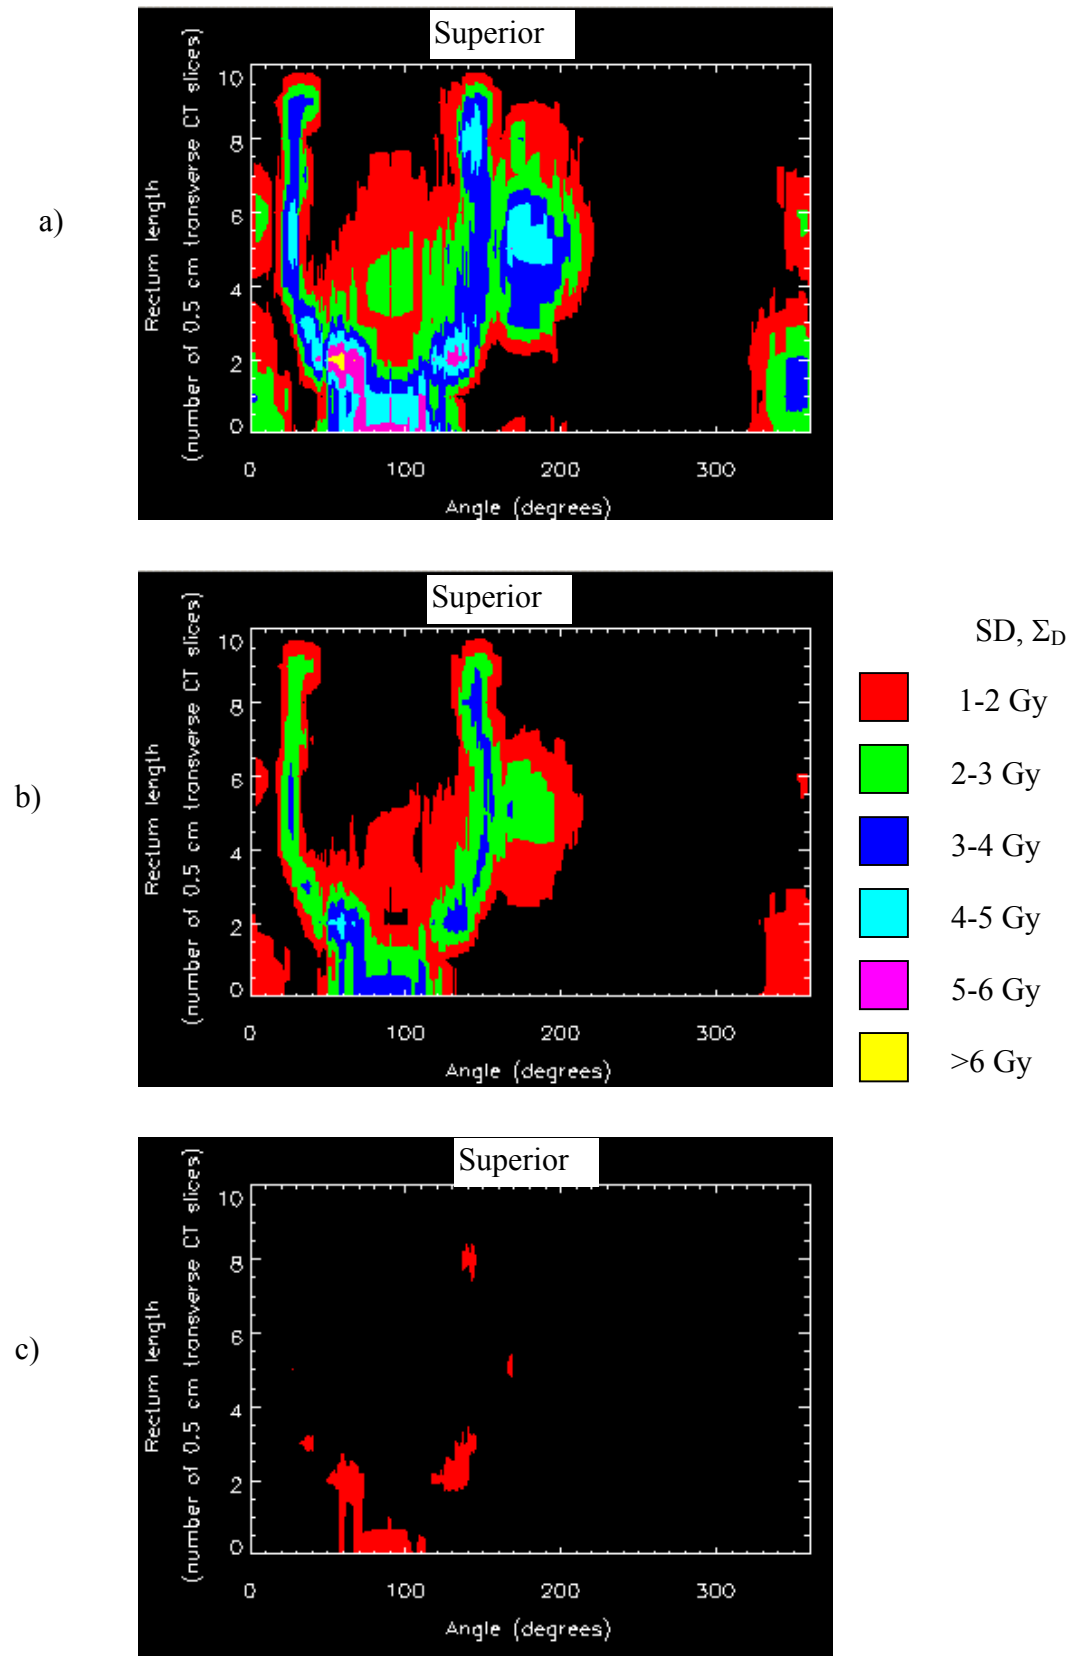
The standard deviation in rectal wall dose calculated with 5 mm margin and a) one pretreatment CT scan with, b) two pretreatment CT scans, and c) infinite pretreatment CT scans. Orientation: Left=0°; Anterior=90°.
